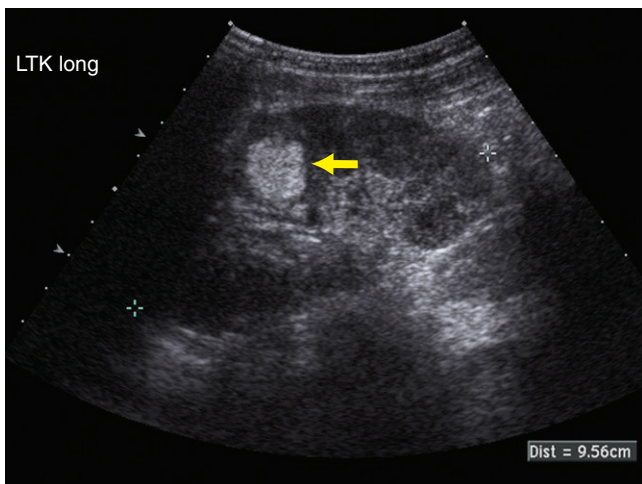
Real-time ultrasound examination of the left kidney demonstrates a well-demarcated echogenic mass (arrow) within the mid pole of the left kidney.
